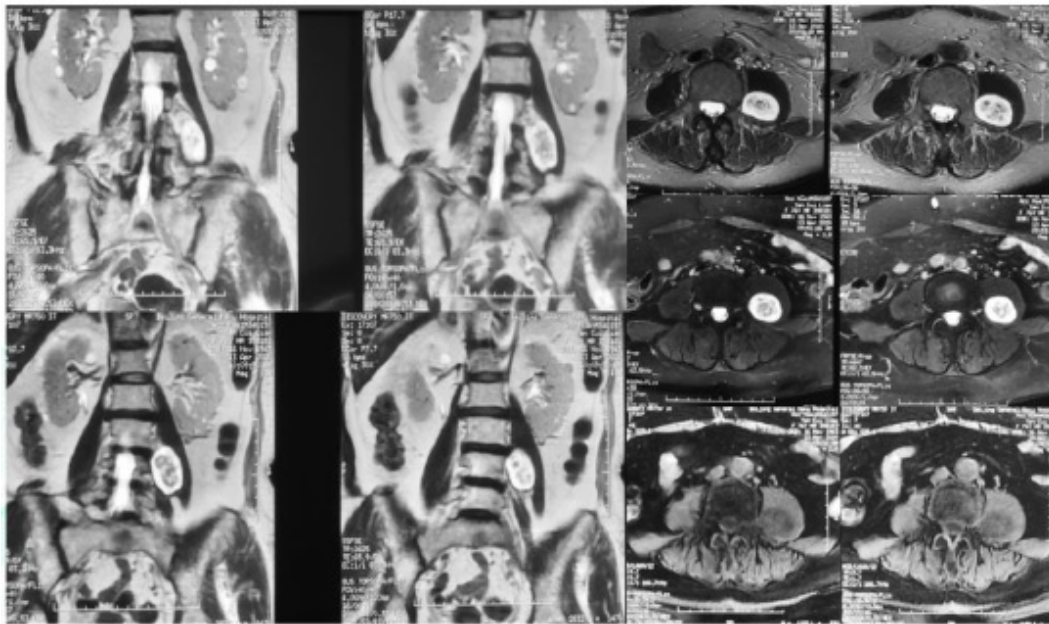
Coronal and axial T1- and T2-weighted MRI scans of the patient diagnosed with a Schwannoma in the left psoas major likely emanating from the L3/4 level.
